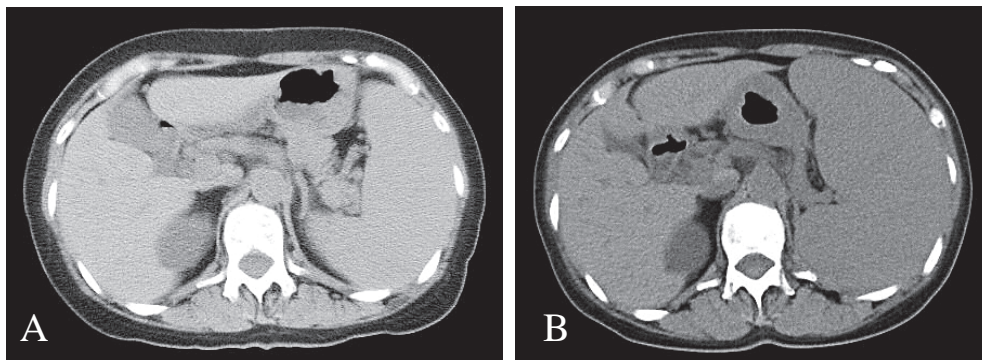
Computed tomography of the abdomen. (1A) Enlarged spleen in May 2006. (1B) Markedly enlarged spleen in April 2008, just before splenectomy.
